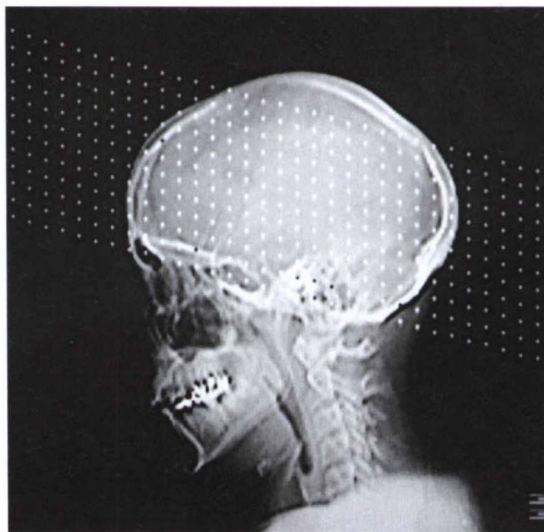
CT localizer (scout) image of skull.
